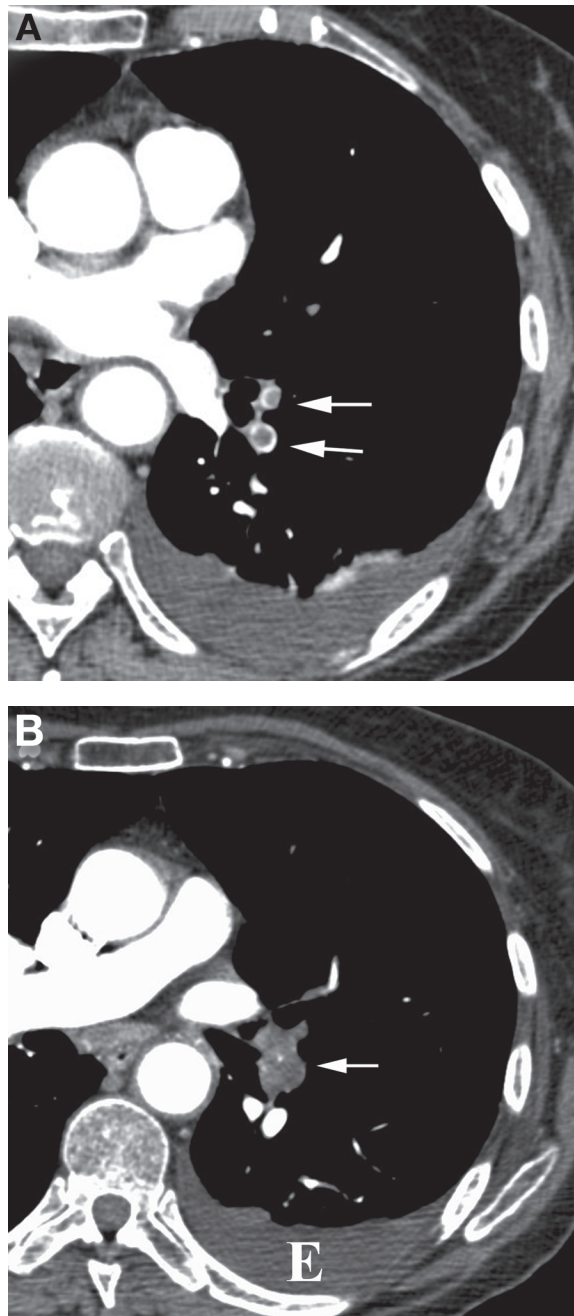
Appearances of acute pulmonary embolism on computed tomography. (A) Filling defect surrounded by rim of contrast (arrows). (B) Complete vascular cut-off (arrow) with absent distal flow. Note also left pleural effusion (E).
